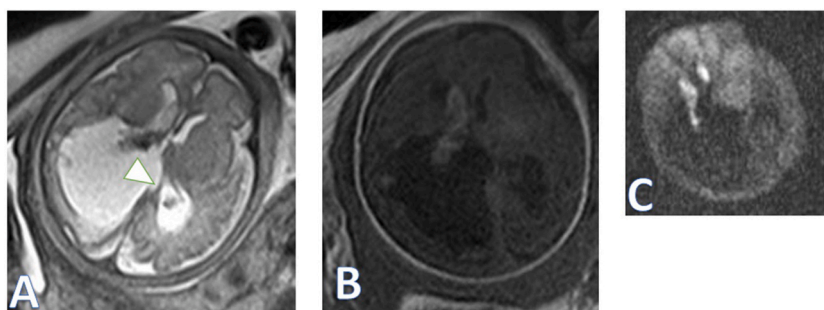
A 25-GW singleton pregnancy. The GM-IVH mainly seen on one side of the lateral ventricle with both obvious enlargement of the ipsilateral posterior horn of the lateral ventricle and thinness of the adjacent grey matter in the occipital lobe on T1WI (A), T2WI (B) and DWI (C). The porencephaly was also seen in the occipital lobe (arrowhead). The TOP procedure was performed.
